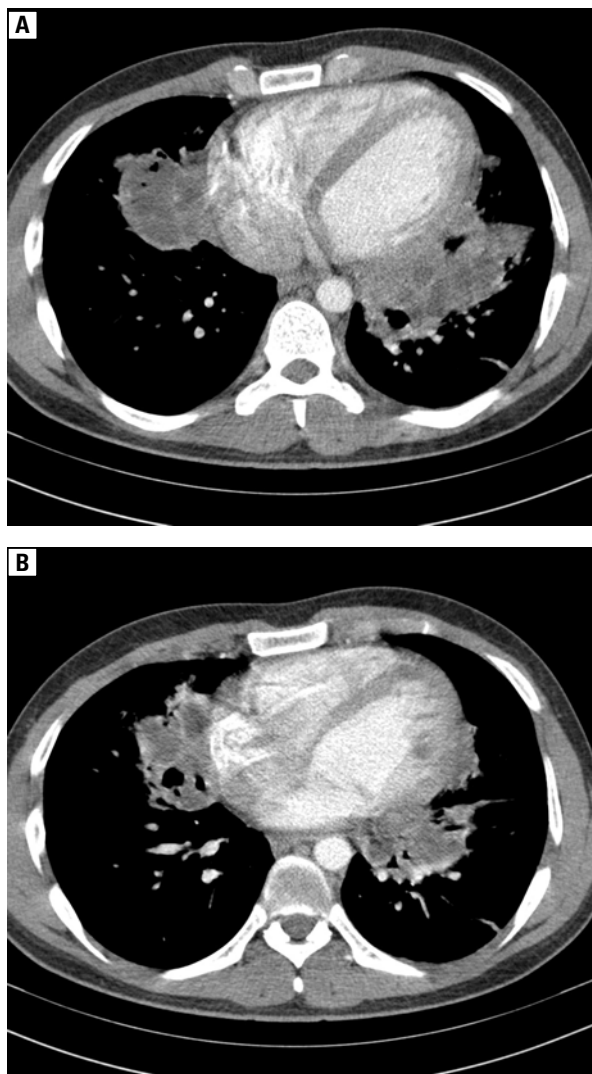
A, B. CT — mediastinal window. Pneumatoceles within consolidative lesions in the middle and left lower lobes
